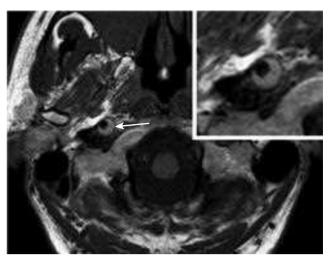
Axial T1-weighted MR image just below the level of the skull base in a patient presenting with right-sided Horner syndrome. There is dissection of the right internal carotid artery. The true lumen is of reduced calibre and appears black, while the crescent-shaped false lumen appears bright due to stagnant methaemoglobin (arrow)
